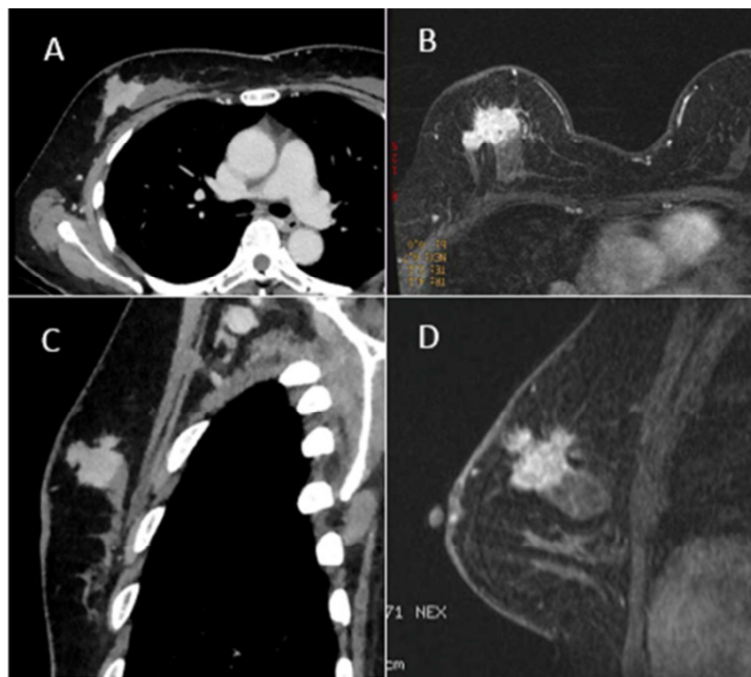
Comparison of representative breast lesion in CT (chest diagnostic series) and MR images. A 56 years' old women with diagnosed invasive ductal carcinoma by biopsy, BMI = 24.5kg/m². A lobulated breast mass with spiculate edge was observed in CT axial images (A), MR axial images (B), CT sagittal images (C), and MR sagittal images (D). The site, disease extent, and enhancement pattern of the breast lesion are similar in CT and MR images, the maximum diameter of the lesion is 35mm in CT and 32mm in MR.
